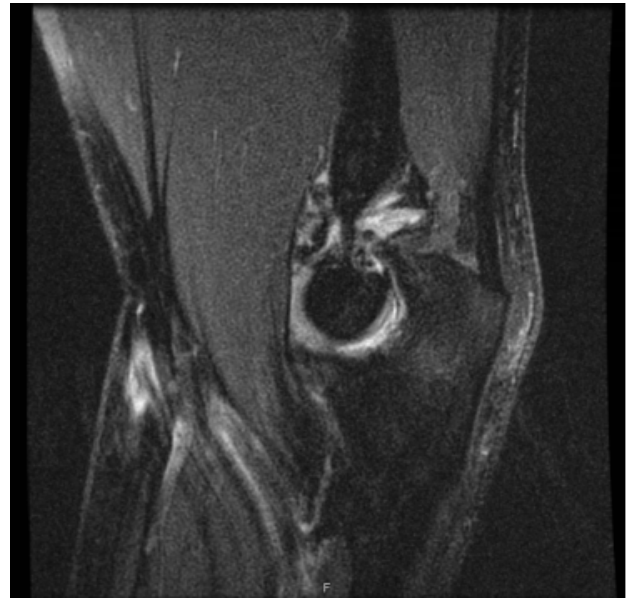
MRI Sagittal T2 sequence showing joint effusion, synovial hypertrophy, low signal loose bodies.
